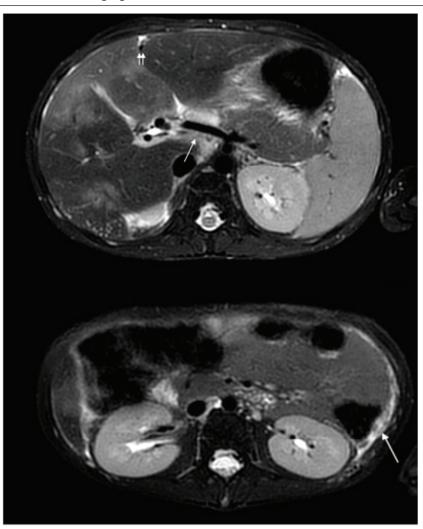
Magnetic resonance imaging of the abdomen with contrast
